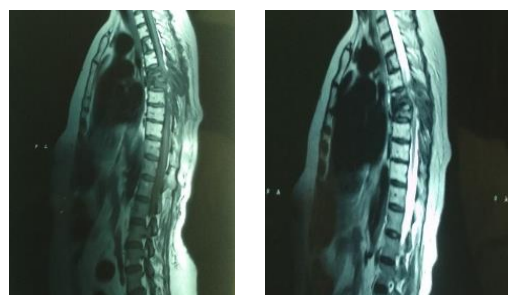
Spinal MRI, T1 and T2 sagittal sequences: Slow spinal cord compression related to an extensive bone tumor from D5 to D4 with vertebral collapse and involvement of the posterior arches.
